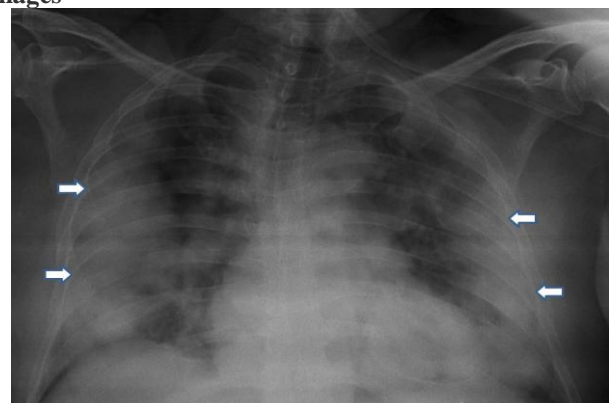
AP chest radiograph reveals areas of consolidations involving bilateral mid and lower zones in a predominantly peripheral distribution (arrows)
